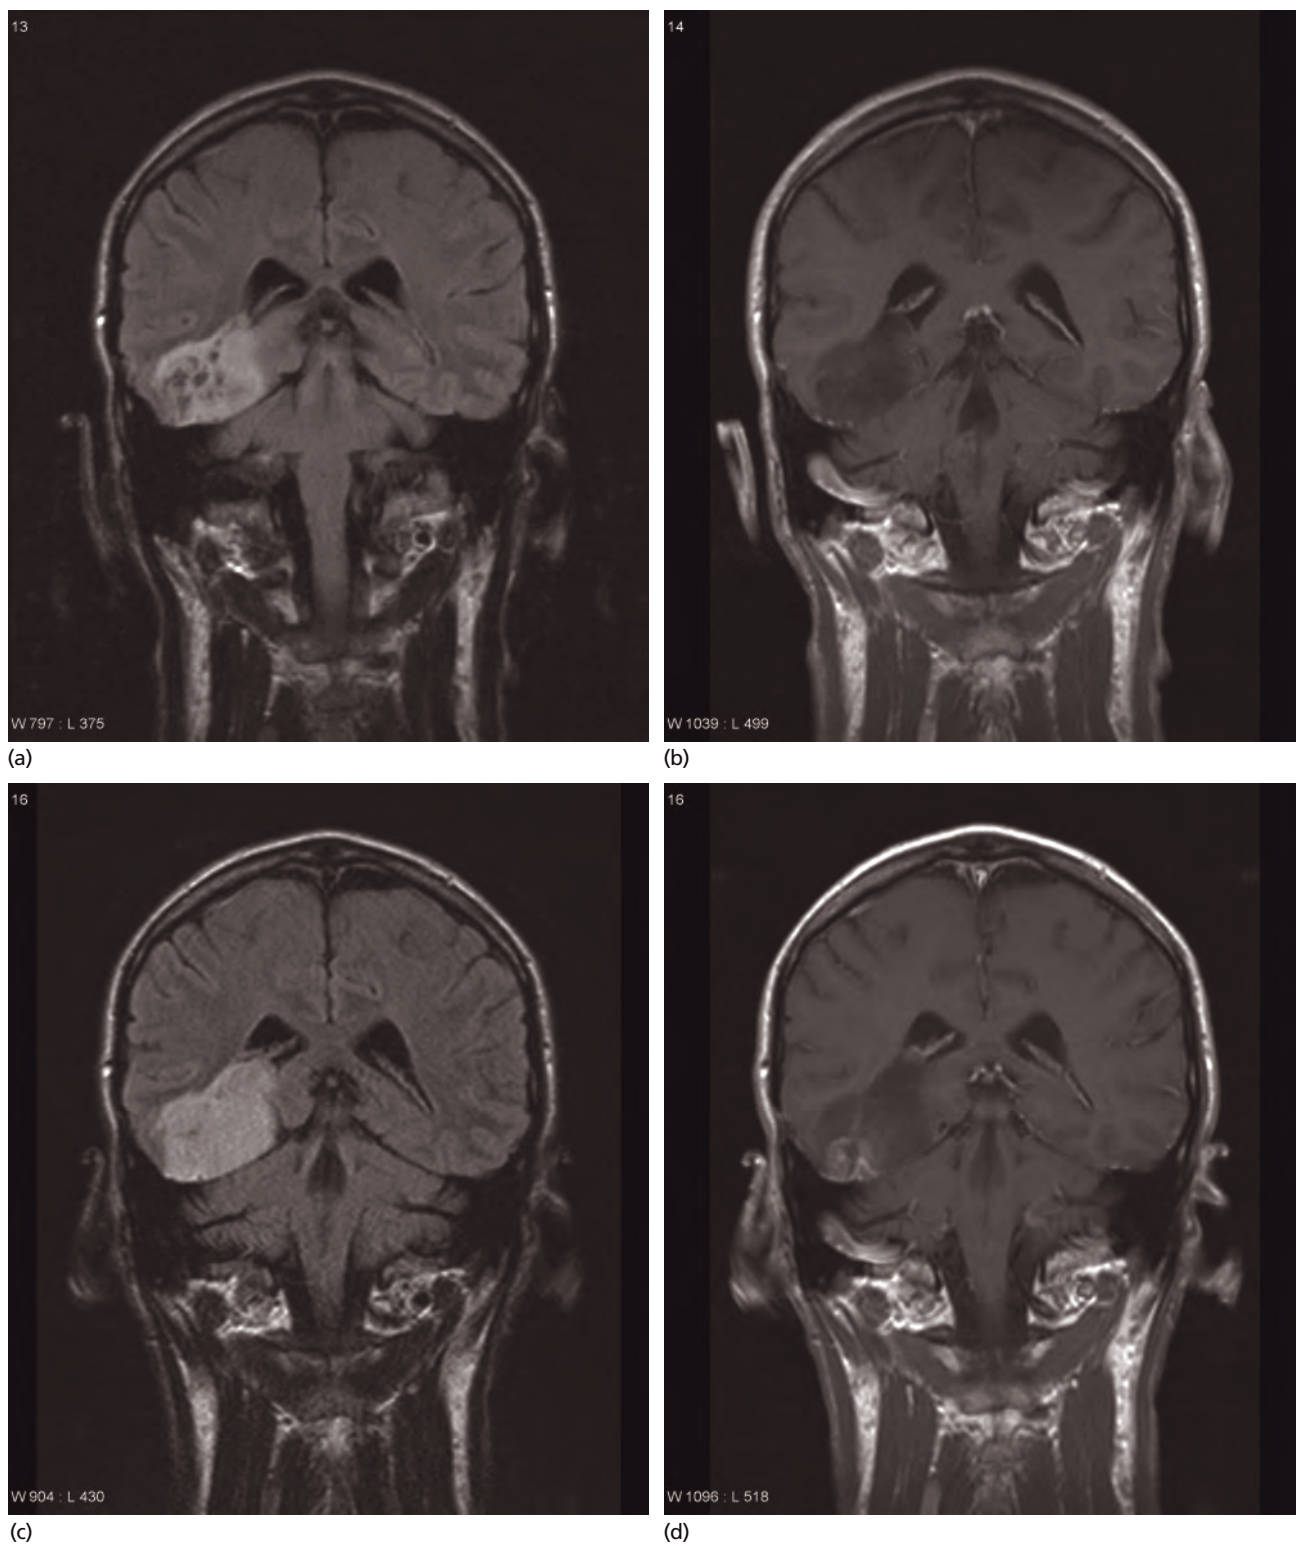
(a) FLAIR image of a WHO Grade II astrocytoma presenting as well-demarcated hyperintense temporal lobe mass containing small cysts. (b) Corresponding contrast-enhanced T1 image does not demonstrate any pathological enhancement. (c) 12 months' follow-up FLAIR image demonstrates tumour enlargement with disappearance of cystic elements. (d) 12 months' follow-up contrast-enhanced T1 image: pathological enhancement at the inferior aspect of tumour. Repeat biopsy confirmed progression to WHO Grade III astrocytoma.
